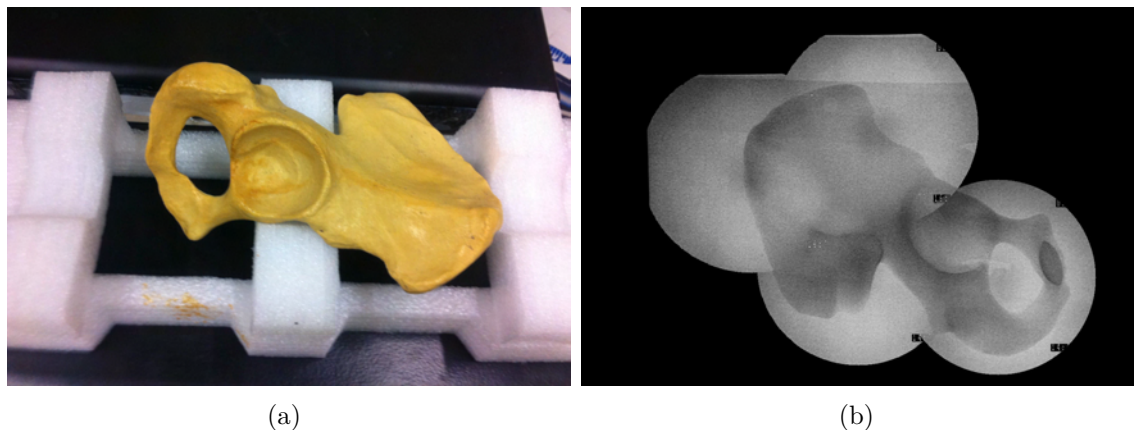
(a) The right half of a plastic pelvis; (b) A parallax-free panoramic X-ray image of the right half of a plastic pelvis.
